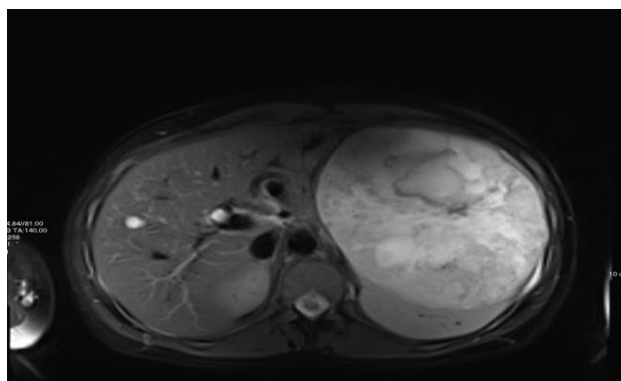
T2-weighted magnetic resonance images. Enlarged spleen with a heterogeneous appearance, with solid areas, cystic formations and a discrete hemorrhagic component.
